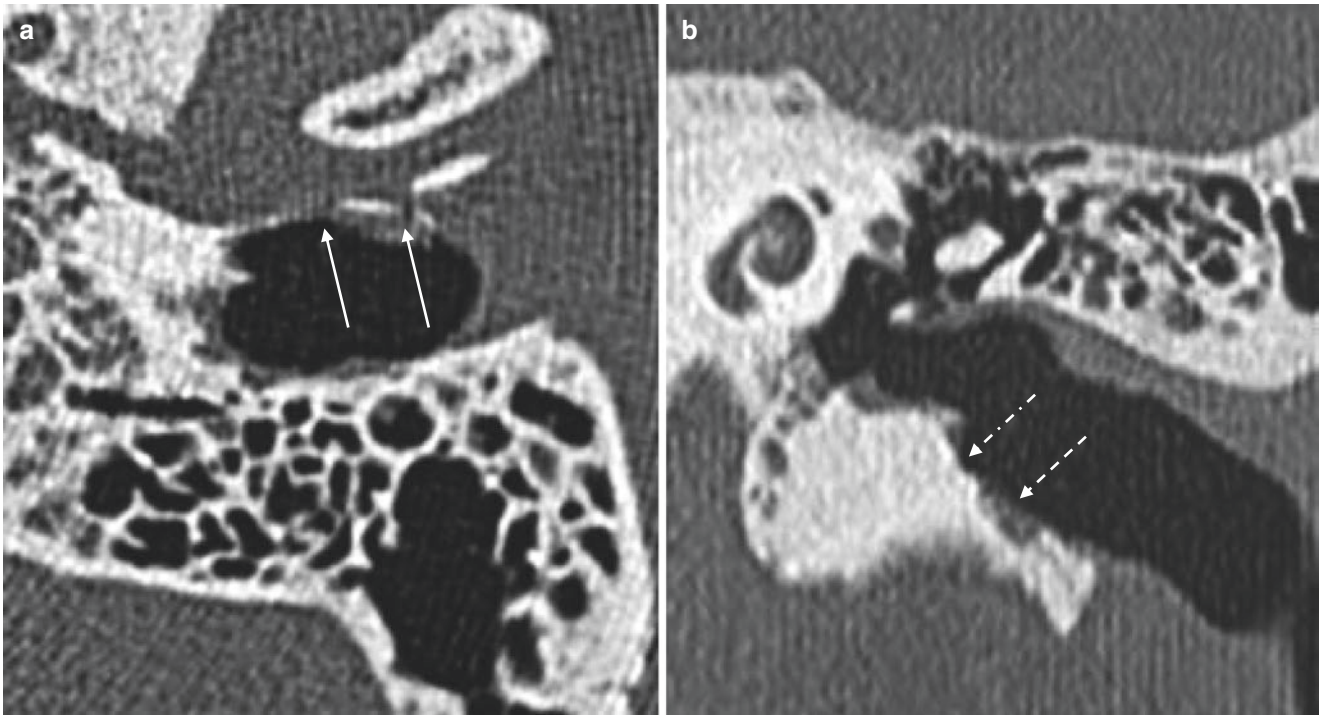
Osteoradionecrosis of the temporal bone. (a) Axial CT and (b) Coronal CT images showing erosion (dashed arrows) and dehiscence (thin arrows) of the antero-inferior external auditory canal.
